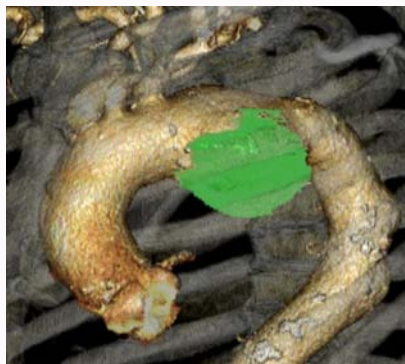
Three-dimensional preoperative computed tomography.
